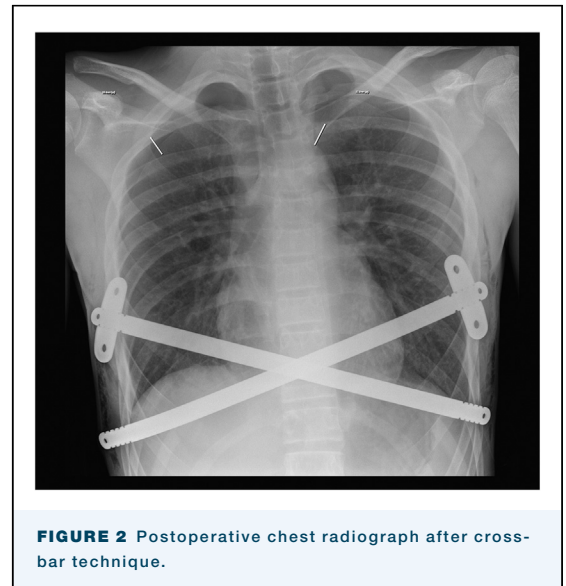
Postoperative chest radiograph after cross-bar technique.
